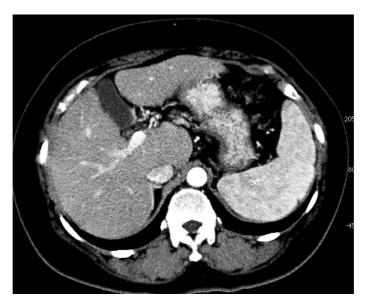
Abdominal CT showing liver deformity and splenomegaly, indicating advanced chronic liver disease. No hepatocellular carcinoma or ascites was evident.
